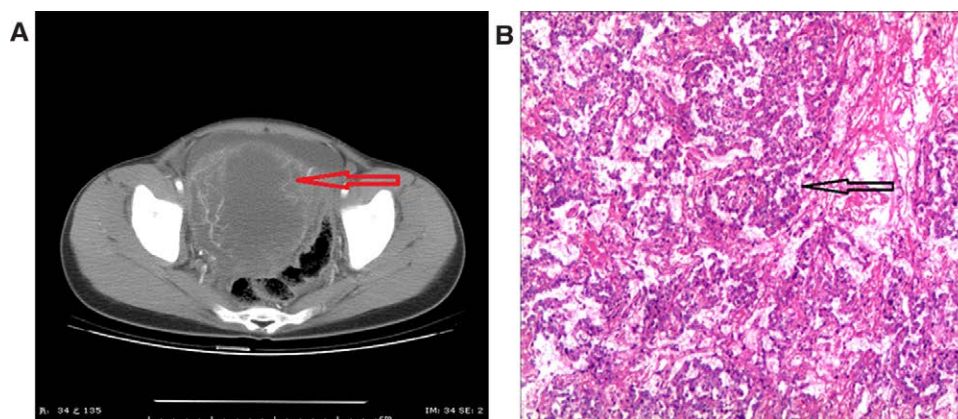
Computed tomography imaging and pathological findings of patients diagnosed with YST. (A) Computed tomography scan on admission. (B) Pathological features of YST. The red arrow indicates the tumor. The black arrow indicates typical pathological signs. YST = ovarian yolk sac tumor.
